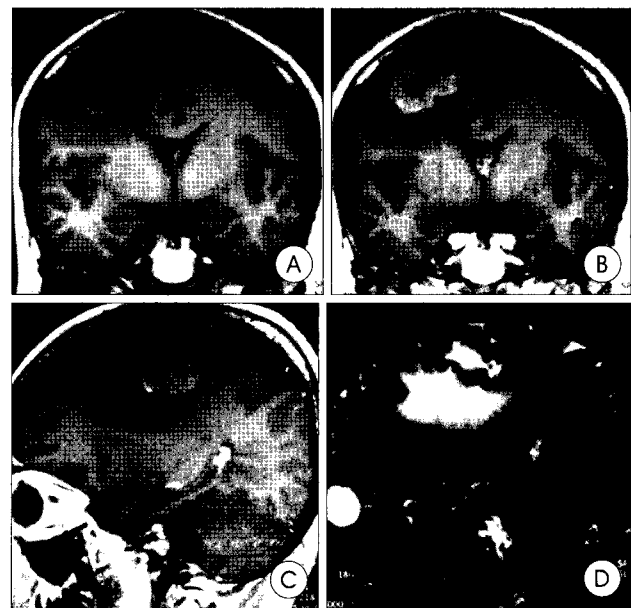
Preoperative magnetic resonance(MR) imaging reveals a well demarcated tumor in the right frontal region. T1 coronal (A), T1 enhanced coronal (B), and T1 enhanced sagittal MR image (C) show homogeneous enhancement of mass lesion with central necrosis and no definite dural attachment. T2 sagittal MR imaging (D) shows peritumoral edema at inferior side.
